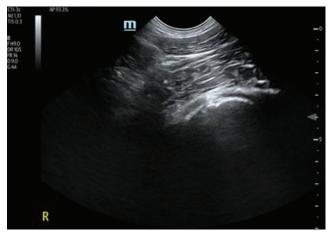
Ultrasound image with curvilinear transducer of a normal psoas muscle, with hyperechoic striations, overlying the right iliac crest (yellow arrows).
